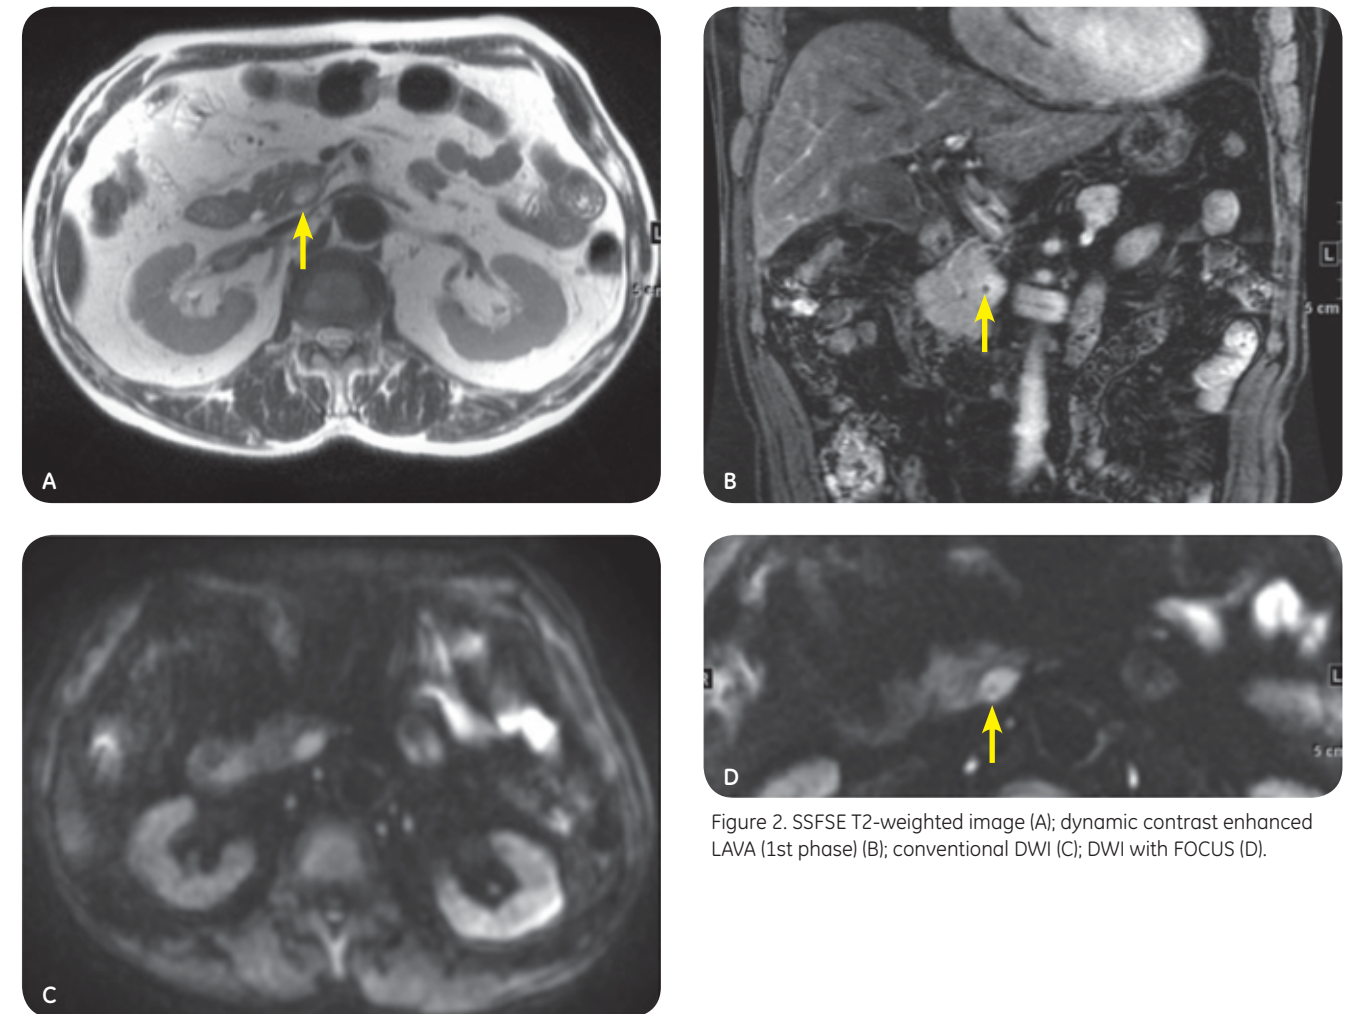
SSFSE T2-weighted image (A); dynamic contrast enhanced LAVA (1st phase) (B); conventional DWI (C); DWI with FOCUS (D).
